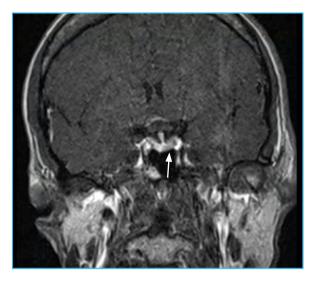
MRI performed in January 2010 showed a hypointense area measuring 6×4 mm, which may correspond to a microadenoma
